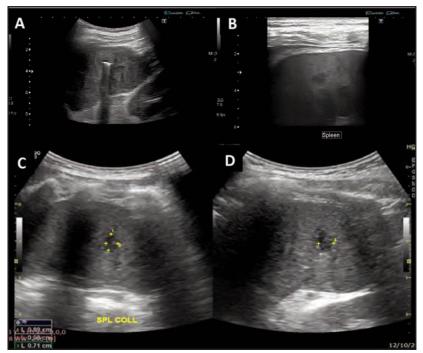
1A (on curvilinear probe), 1B (linear probe)-Ultrasound images upon initial presentation showing ill-defined hypoechoic liver lesions with echogenic focus with reverberation artifacts. 1C, 1D - Ultrasound reassessment 1 month post treatment showing smaller splenic lesion measuring less than 1cm with no obvious air focus noted within.
